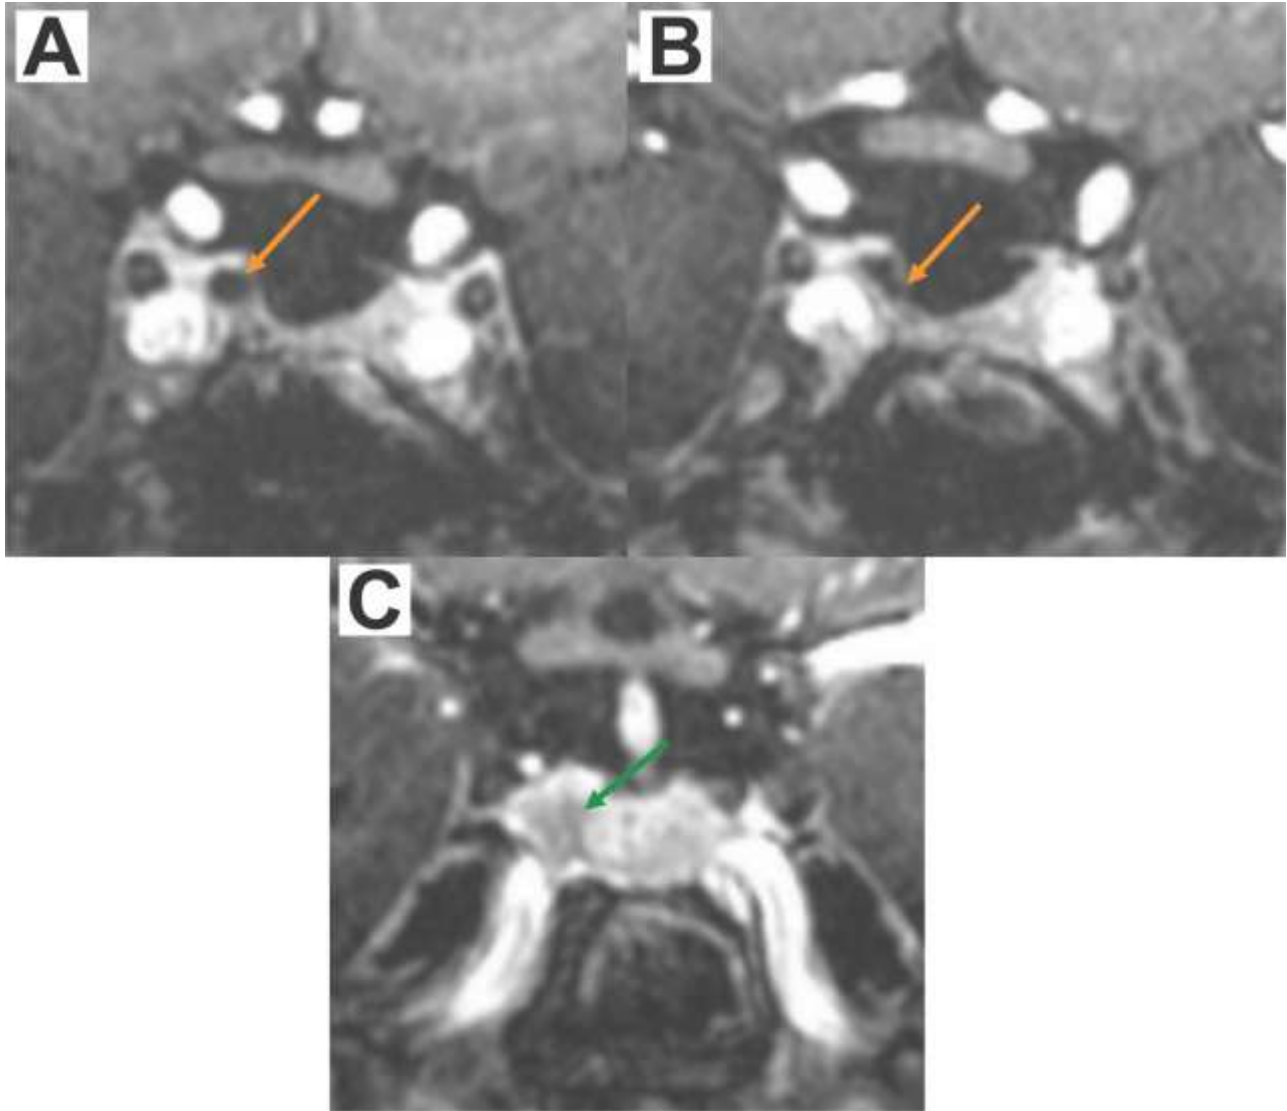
A 45-year-old female with increased prolactin levels who had a transnasal endoscopic pituitary adenoma resection and underwent a follow-up with a 7T MRI due to increased prolactin levels two months after the surgery. A) Coronal post-contrast 3D-FS-T1 MPRAGE shows a hypointense cystic structure mimicking a cystic adenoma located at the right ventral aspect of the adenohypophysis (orange arrow) with indistinct margins. B) When scrolled posteriorly, the cystic mass connects with CSF. Thus, this was favored to be entrapped CSF in the operation field. C) When scrolled even further in the posterior direction, there was a more hypointense focus with indistinct margins in the right aspect of the adenohypophysis, considered as a residual adenoma (green arrow).
